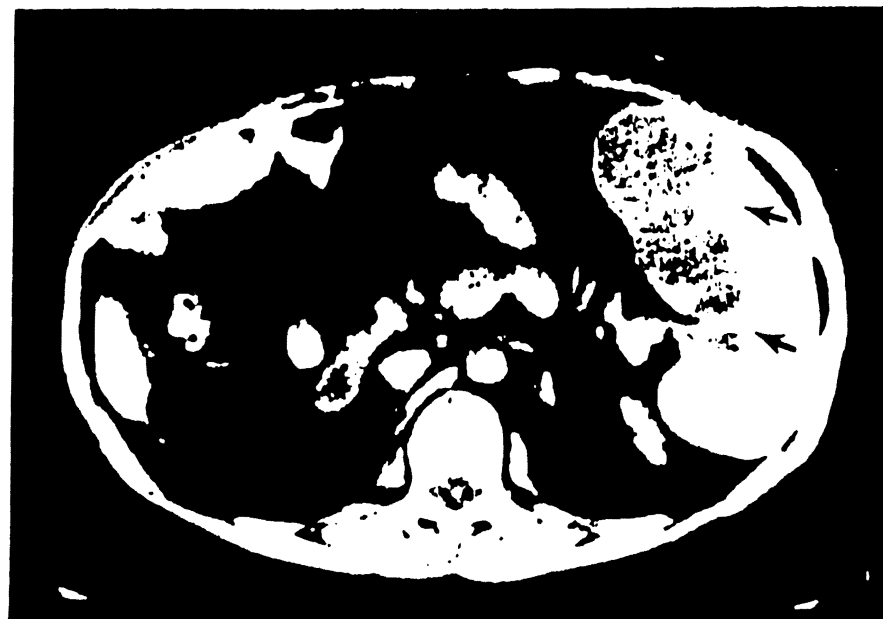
CT scan of abdomen demonstrating splenic infarcts in a patient who required splenic artery ligation at the time of transplant. Patient developed fever and left upper quadrant pain that responded to a course of antibiotics without needing splenectomy.
